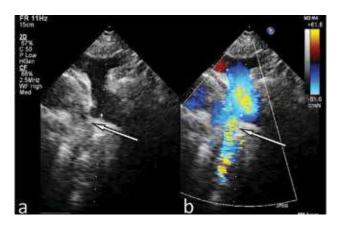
Patient R., 20 years old: transthoracic echocardiography. Suprasternal position along the long axis: a - B-mode; b - color Doppler; white arrow indicates the site of stenosis
